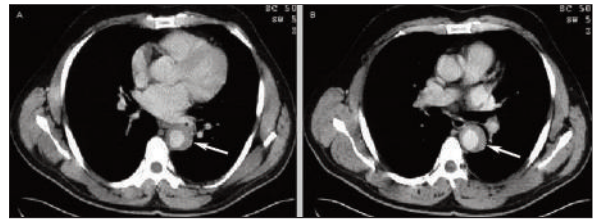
CT image showing haematoma as a high density reflection and wall thickness.
